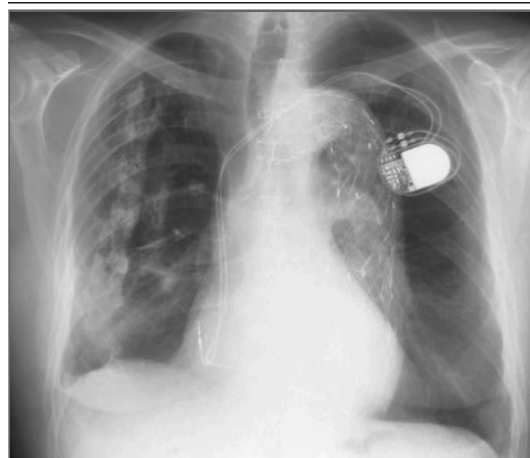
Radiograph in a Patient Who Underwent Four Lifesaving Procedures between 1949 and 2002.
